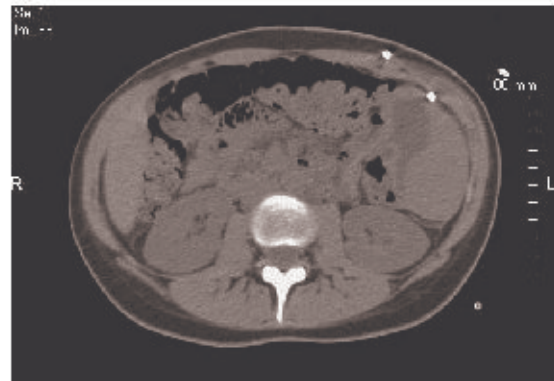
Postdrainage-abdominal CT revealed cyst collapsed with partially calcified walls (circle); the arrows indicate site of entry and exit of "pigtail" percutaneous US-guided drainage.
